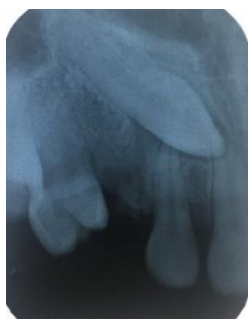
Periapical radiograph of the remaining root of tooth 53.
